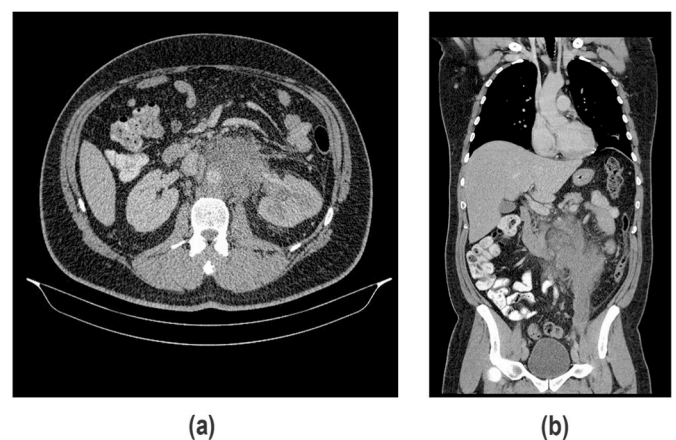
a) axial and b) coronal CT scan shows enlarged retroperitoneal and inguinal lymph node conglomerate up to 9 cm in largest diameter.
